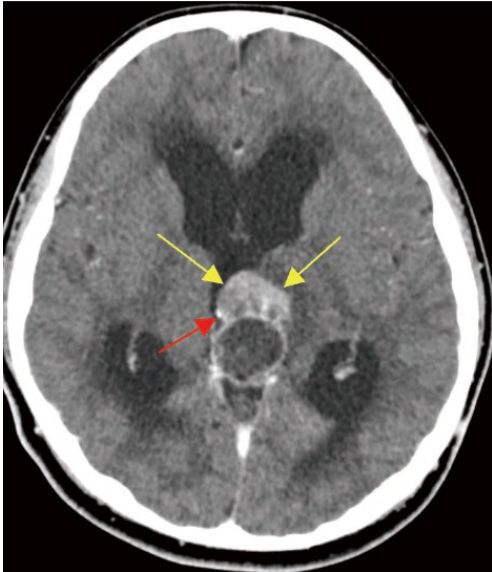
Preoperative contrast CT scan of the brain shows a heterogeneously enhancing, mixed solid cystic mass at pineal gland region (yellow arrows) with peripheral calcification (red arrow) consistent with pineal gland tumour causing obstructive hydrocephalus and cerebral oedema.
